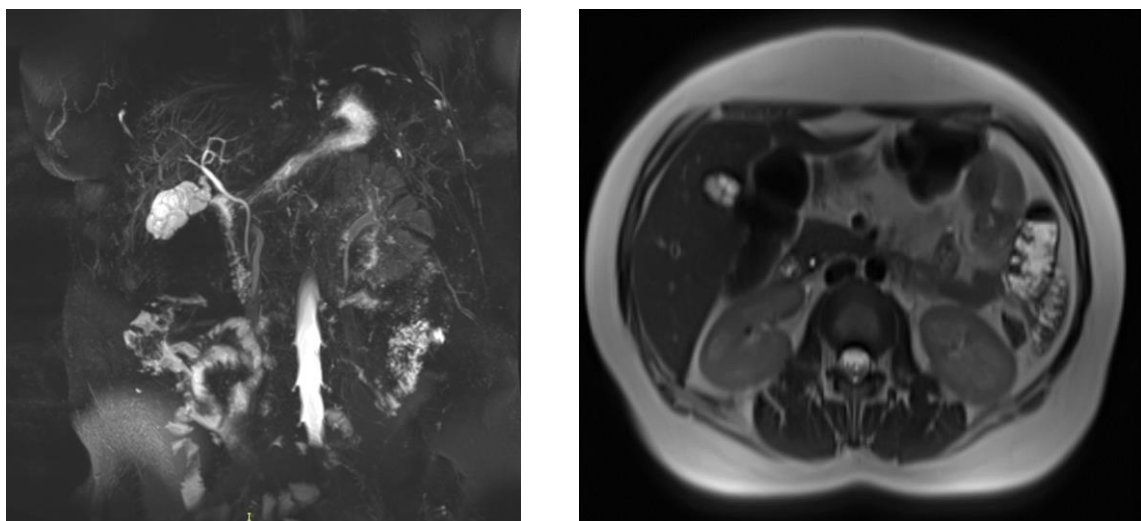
gall bladder with thin multiseptated high-signal intensity cystic mass-like with scalloping margin as seen in image (a) MR cholangiopancreatographic and image (b) Axial T2-weighted magnetic resonance image.
